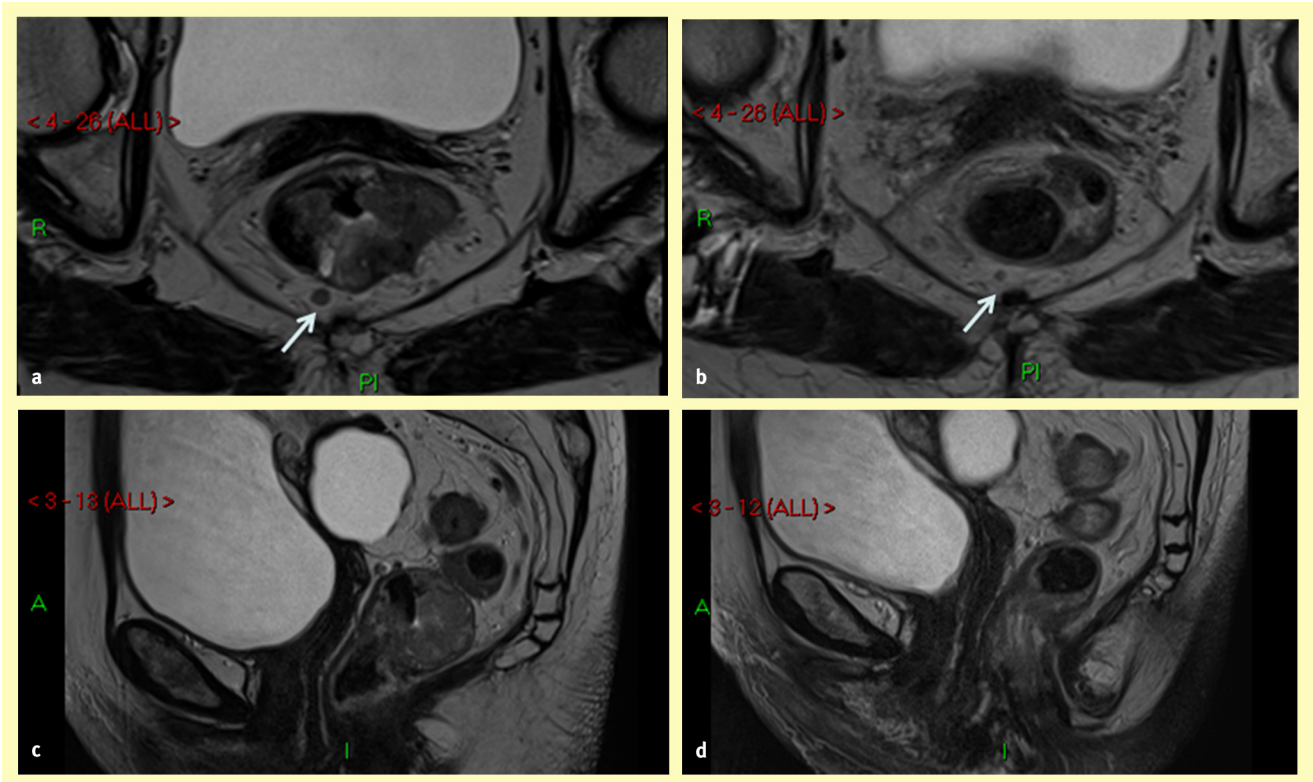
MRI rectal cancer prior to long-course chemoradiation (a, c) showing mesorectal lymph node (arrow) which is reduced in size post-treatment (b). Sagittal sections show an overall reduction in tumour bulk from pre-treatment (c) to post-treatment (d). (Images courtesy of Dr Stephen Glancy, Consultant Radiologist, Western General Hospital, Edinburgh.)
